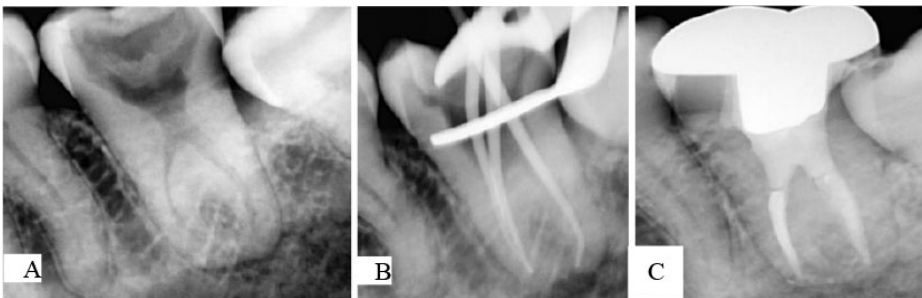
(A) pre-operative radiography, (B) trial master point radiography, (C) post-operative radiography with zirconia endocrown.
